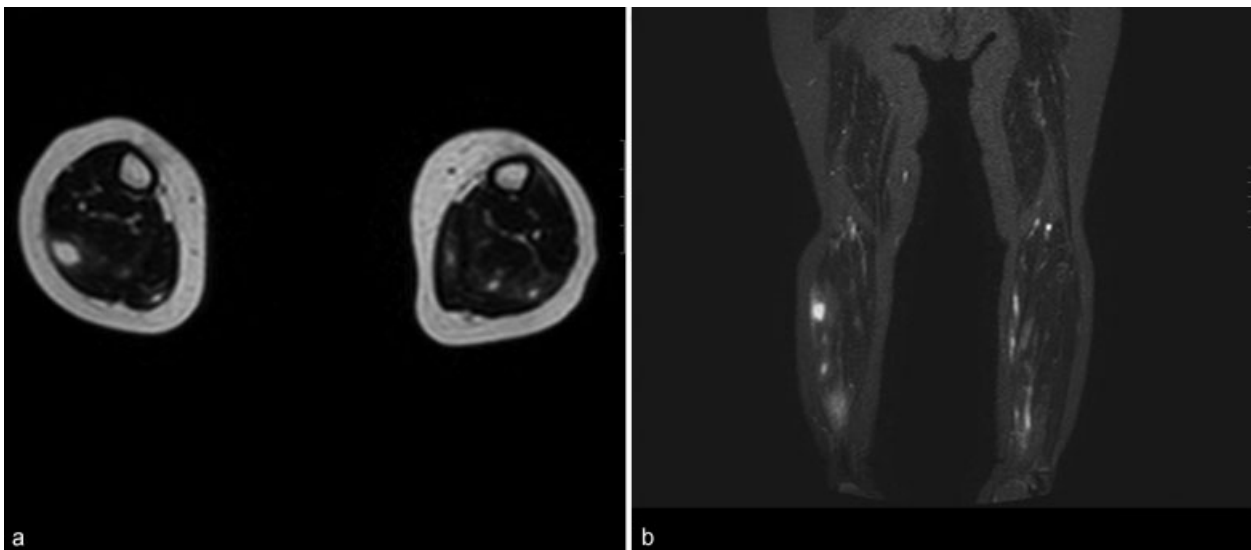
Sagittal (a) and coronal (b) lower limbs magnetic resonance imaging (MRI) indicative of multiple bilateral abscesses in both gastrocnemius muscles with smooth peripheral rim enhancement after contrast administration. Postgadolinium scans demonstrated pathological enhancement of its fascia with subcentimetric lymph nodes in popliteal fossa.
